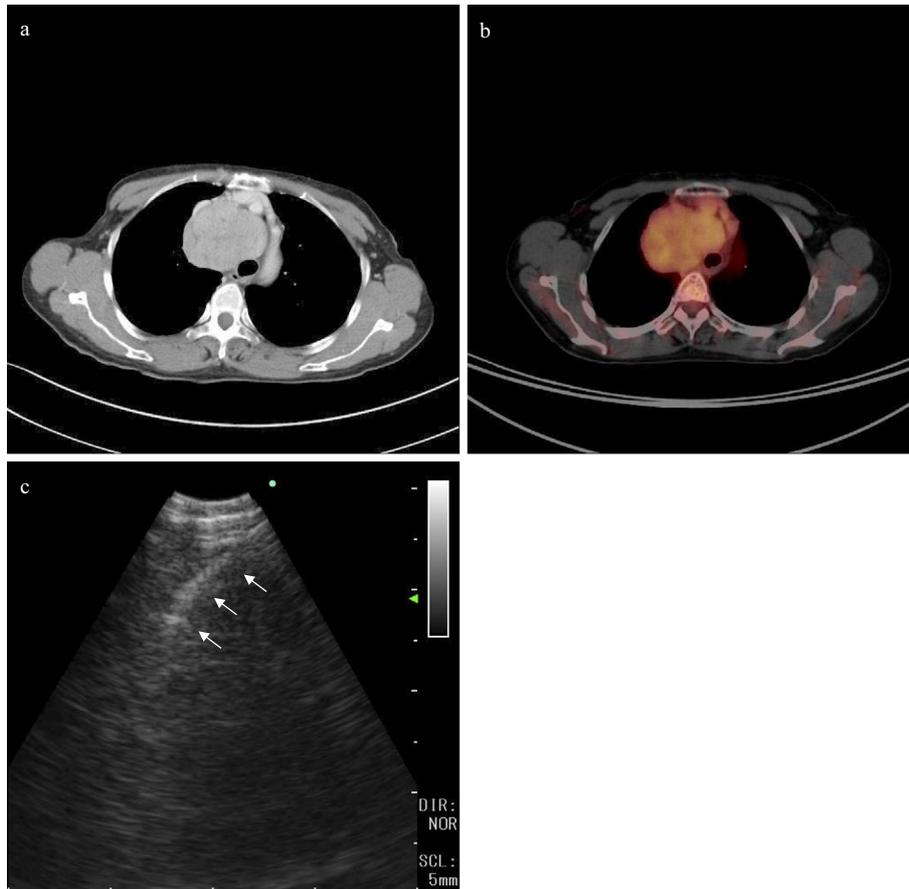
Case 2. a: Contrast-enhanced chest CT showing a heterogeneous mediastinal tumor displacing the trachea greatly to the left. b: A PET/CT scan showing the insignificant uptake in the tumor. c: Endobronchial ultrasound showing needles (arrows) penetrated through a mediastinal tumor with a comparatively low echoic pattern.
